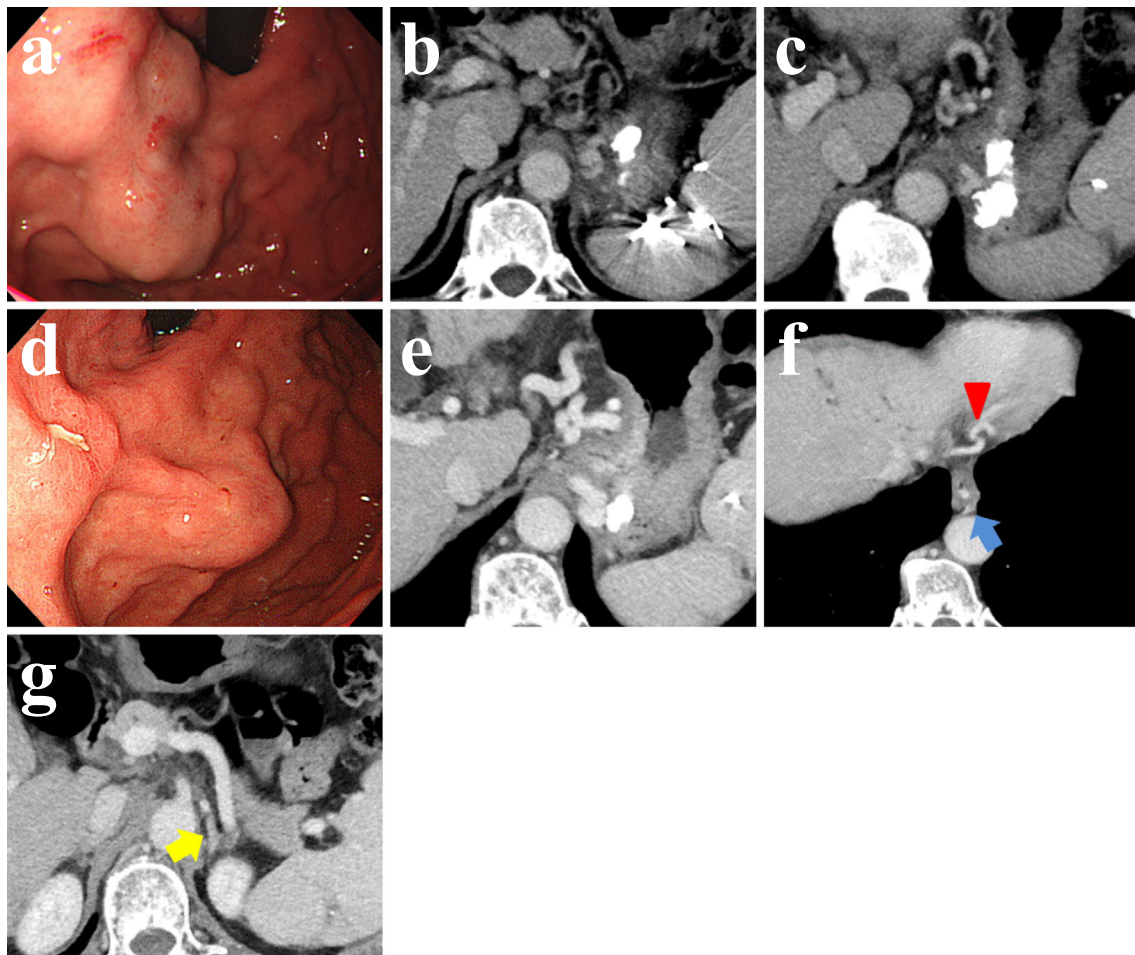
One week after shunt-occluded endoscopic injection sclerotherapy (SO-EIS), esophago-gastroduodenoscopy (EGD) and enhanced computed tomography (CT) showed complete thrombosis of the isolated gastric varices (IGVs) and afferent vein (a-c). Three months after SO-EIS, EGD showed that the IGVs had shrunk (d).
